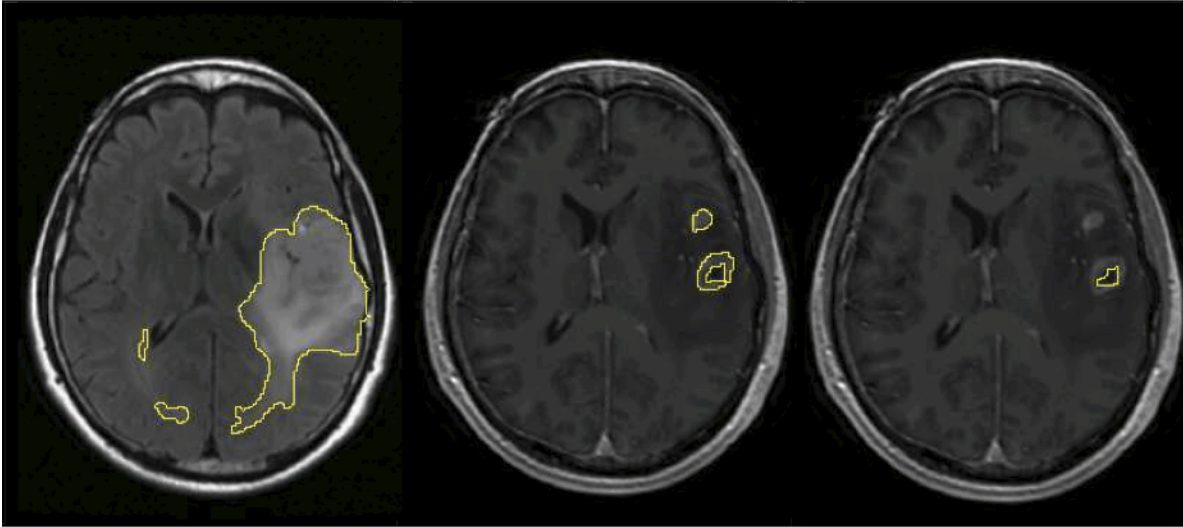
Regions of interest: FLAIR abnormality regions (T2all), contrast enhancing lesion (CEL), and necrotic region (NEC)
